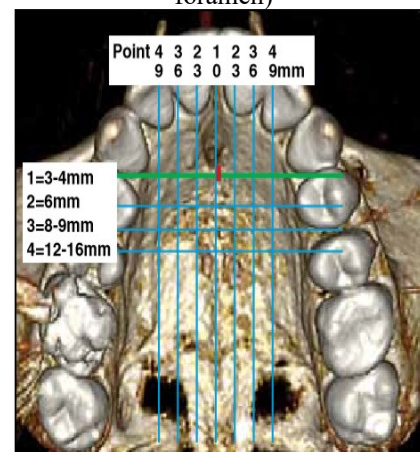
Palatal vault grid used in analysis of radiographic and clinical landmarks (green line indicates anterior limit for favorable palatal TADs insertion; red square shows distance from incisive foramen to reference line)
